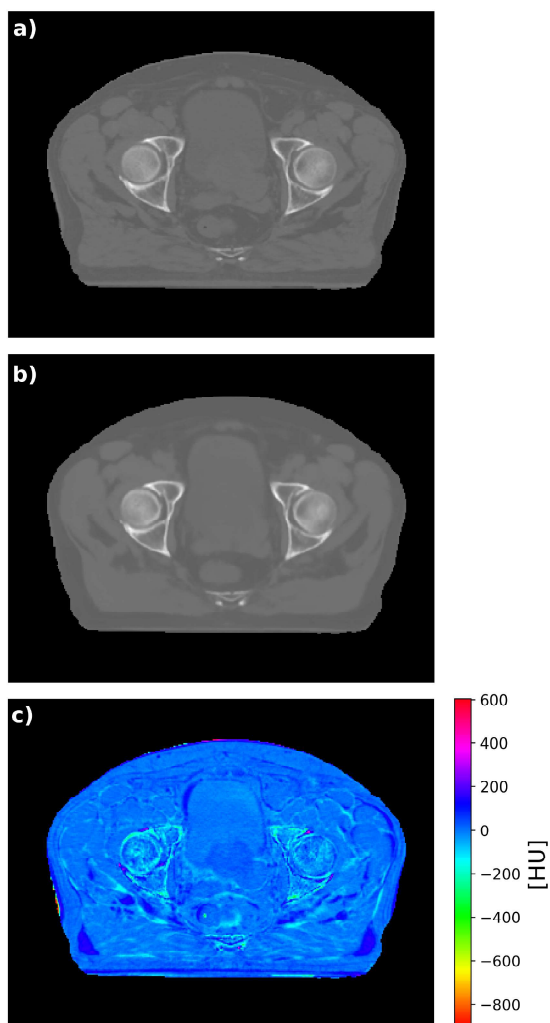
Exemplary case of CBCT to sCT conversion. In panel a and in panel b the pCT and the sCT are depicted respectively. Panel c shows the error distribution map between pCT and sCT.
